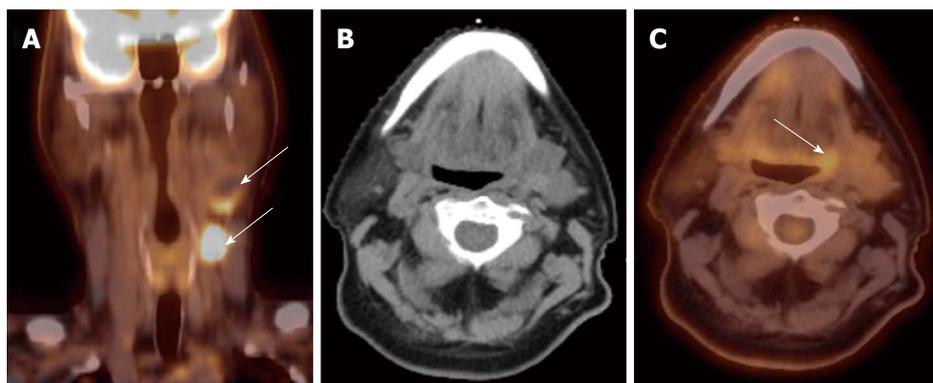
Computed tomography. A: A patient presented with multiple left neck nodes (arrows); B: The conventional methods as well as the computed tomography (CT) imaging could not identify the primary tumor; C: A positron emission tomography/CT scan showed increased fluorodeoxyglucose uptake in the left base of tongue (arrow) and a directed biopsy of this area confirmed the primary site.
